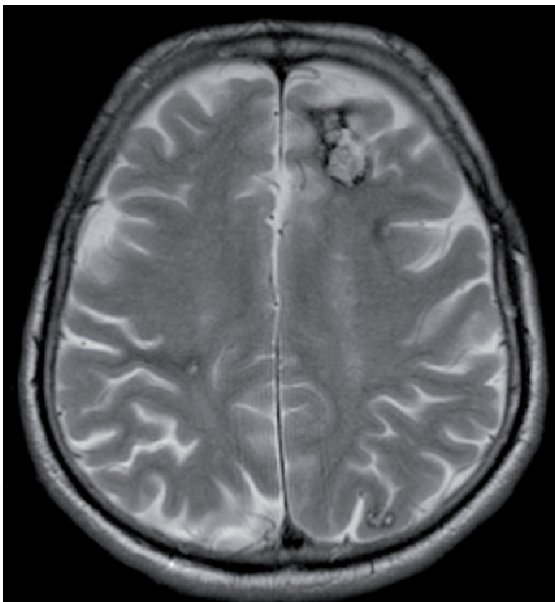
Type IV cavernoma not displayed on T2-weighted sequence.
